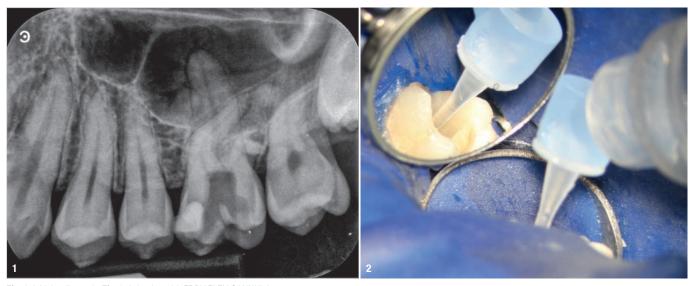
Initial radiograph. Fig. 2: Irrigation with EDDY FLEX.CANNULA.
